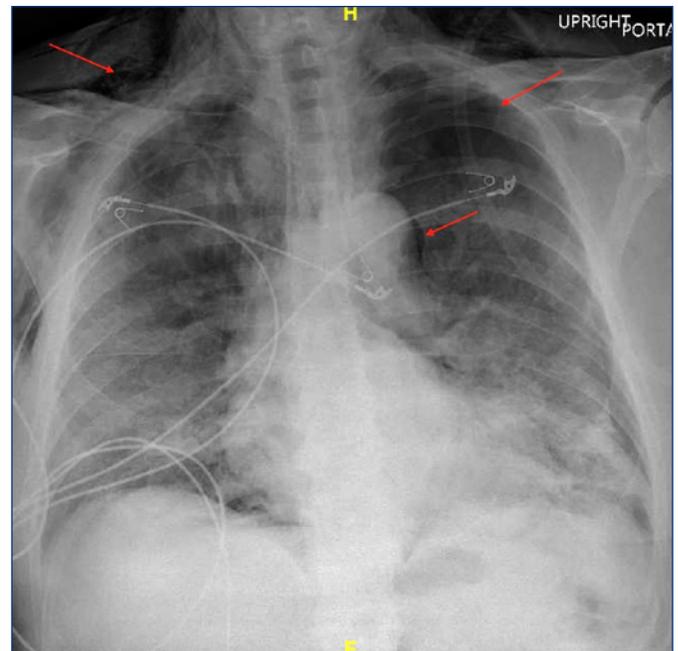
X-Ray imaging of the chest showing multifocal airspace opacities.
